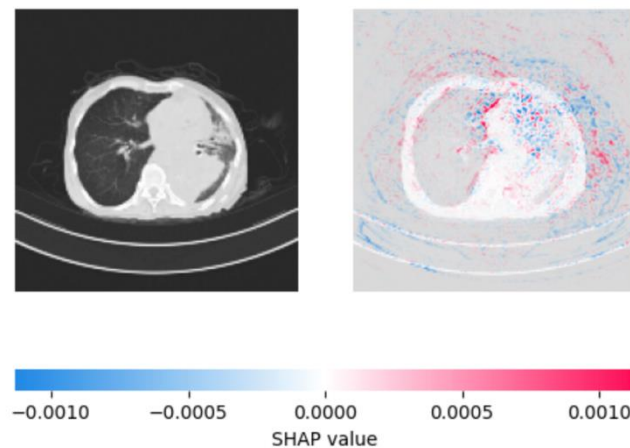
Based on the high SHAP value displayed in the explanation image (second image), we can say the CT image is diagnosed as Cancerous.
